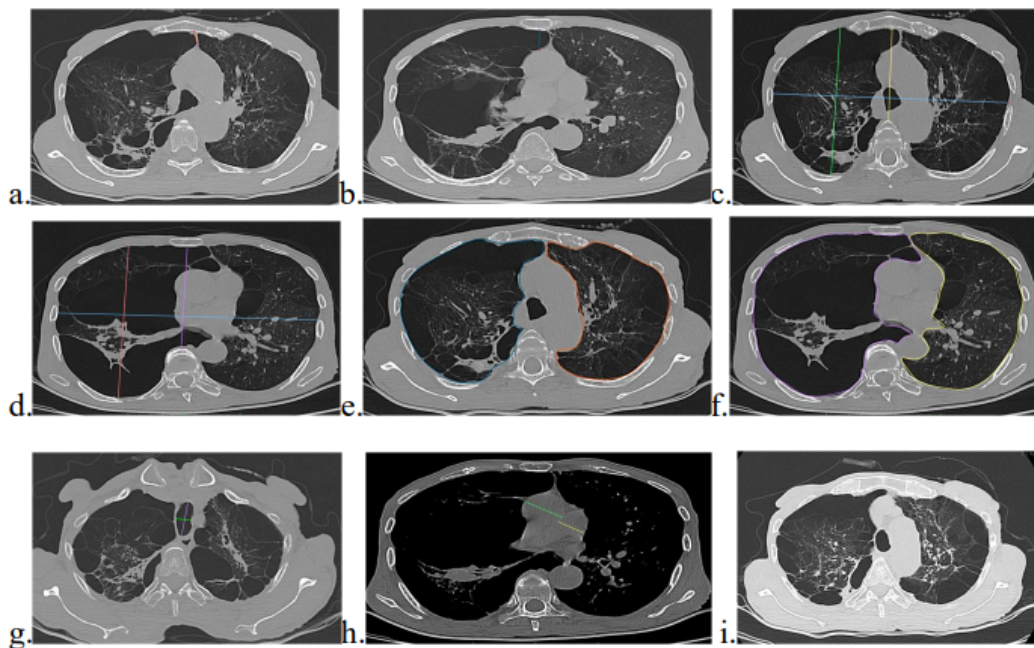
66y, male smoker with productive cough, breathlessness, pedal edema and mild fever. Spirometry: FEV1-28%, FVC-50%, FEV1/FVC < 0.7 consistent with GOLD Stage 4 COPD with HRCT parameters as below.
